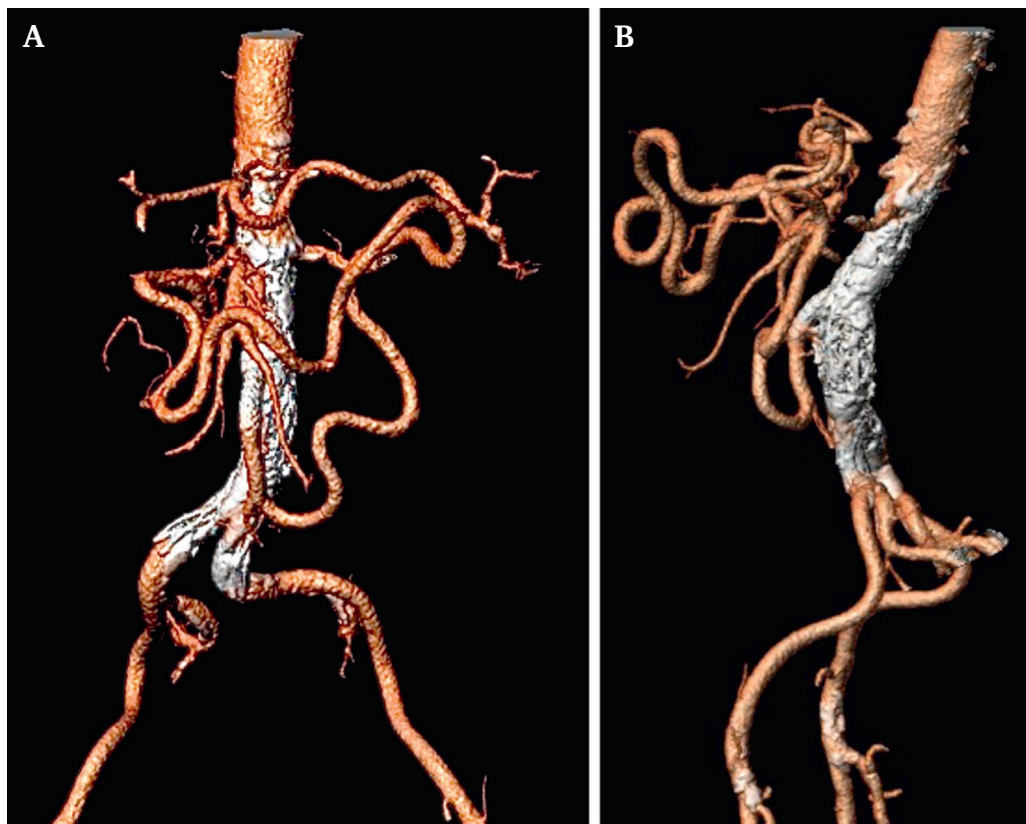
Three dimensional reconstruction computed tomogram at one year follow up (A) Coronal and (B) Sagittal views. There was no evidence of endoleak and the inferior mesenteric artery remained patent. At this time, the patient's aneurysm was completely thrombosed and regressed.
